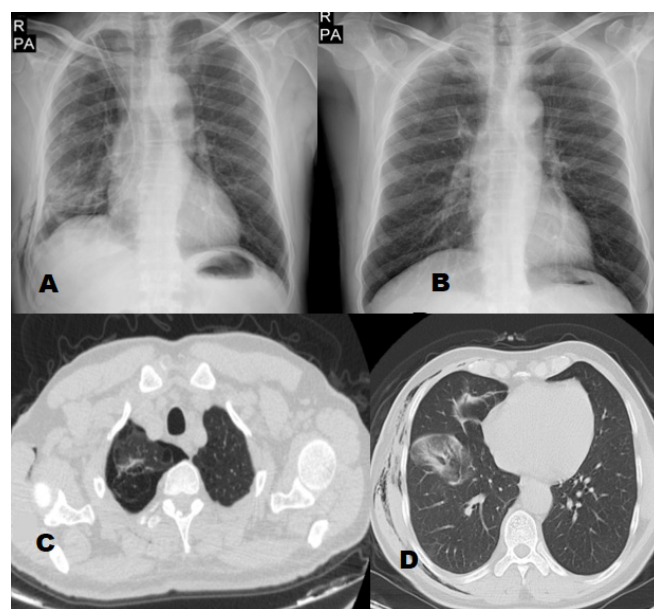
51-years-old male patient admitted to our hospital with chest pain was diagnosed with pneumothorax. Chest X-ray showing chest tube inserted for pneumothorax (A), after tube removal (B), computed tomography showing the parenchymal lesions of PCR test positive patient (C,D).
